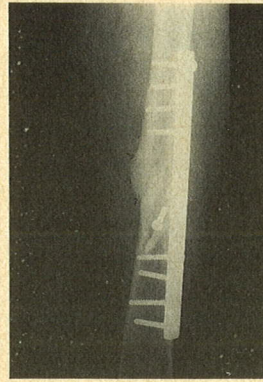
Post-operative radiograph at the end of six weeks. An increase in the density of bone paste is noticed and is seen bridging the fracture site.
